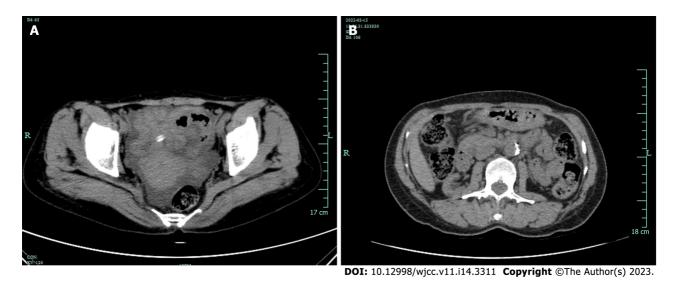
Computed tomography results before and after treatment. A: Before treatment, computed tomography (CT) showed ascites without obvious thickening of the membrane; B: CT reexamination showed that peritoneal thickening has not been completely absorbed caused by peritonitis after treatment.
